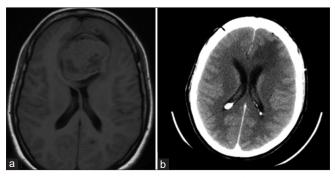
(a) The lesion on an axial section of the preoperative magnetic resonance imaging scan; (b) Postoperative computed tomography head scan showing the subtotal resection of the lesion with decompression of the frontal horns of both lateral ventricles.
